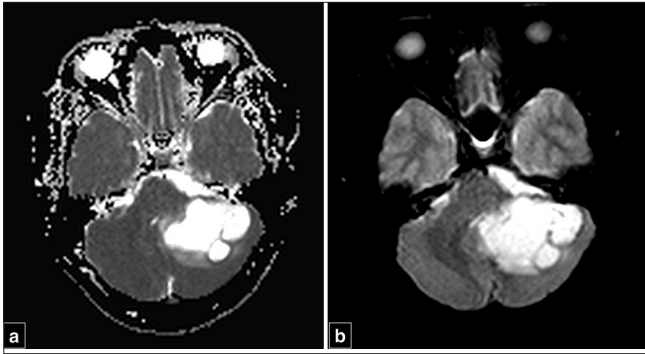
(a) Axial apparent diffusion coefficient magnetic resonance imaging (MRI) sequence and (b) axial TRACE diffusion-weighted MRI sequence showing bright signal on both suggestive of no restriction of diffusion in the lesion.
